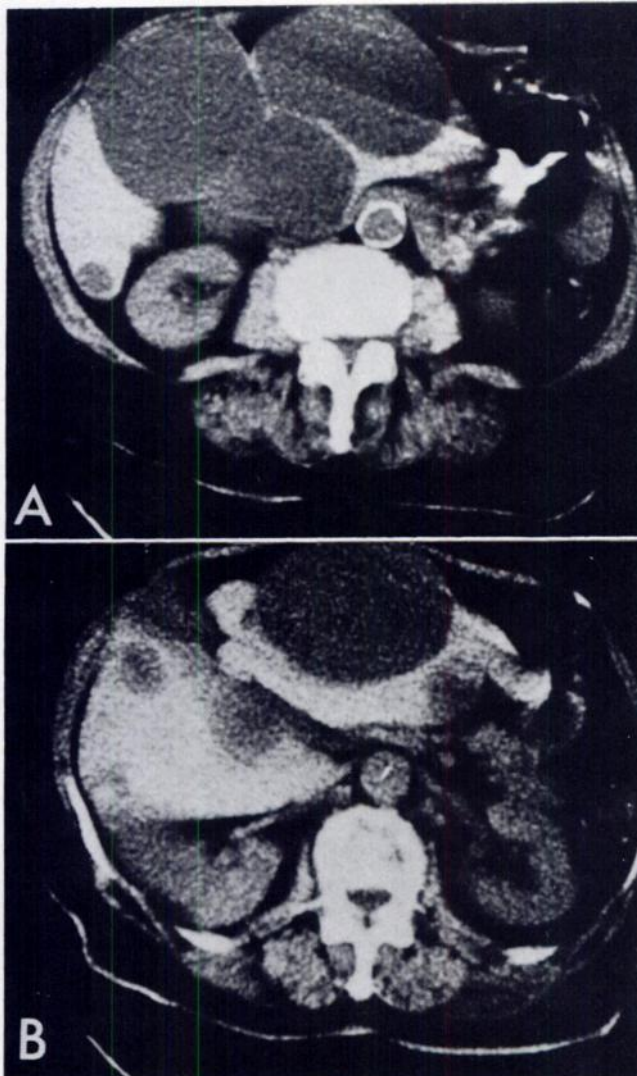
Polycystic liver. *A*, Scan at lower level showing cysts sharply margined and of uniformly low density. Where they are approximated, thin cyst walls can be seen. *B*, Scan at higher level showing some cysts in right lobe with nonuniform density and poorly defined margins, probably because hepatic parenchyma also included in CT section (see fig. 10).
